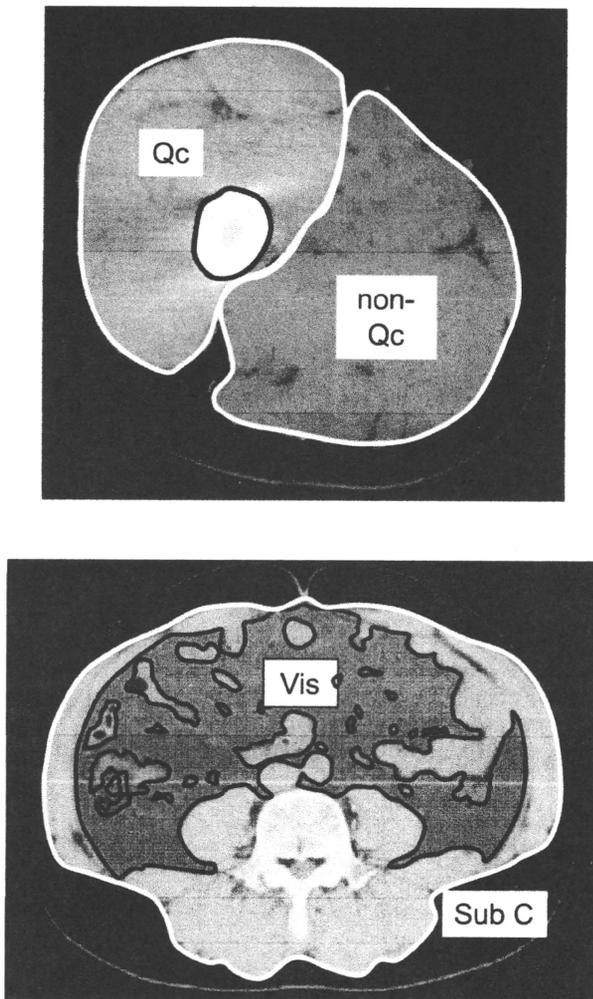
Mid-thigh computed tomography (CT) (top). Quadriceps (Qc) muscle cross-sectional area (CSA) and non-Qc muscle CSA obtained are shown. Abdominal CT at the level of the umbilicus (bottom). Visceral fat area (Vis) and abdominal subcutaneous (Sub C) fat area obtained are shown.
